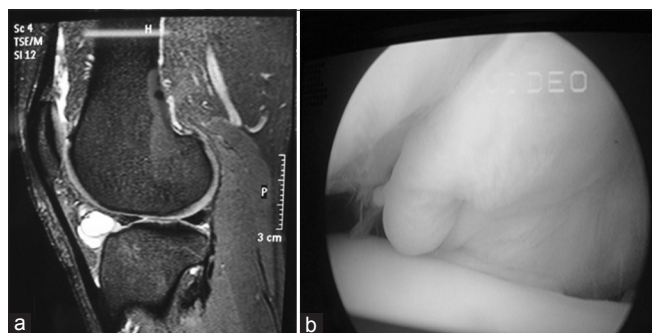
(a) MRI T2WI sagittal images of knee (case 1) showing hyperintense lesion from HFP. (b) Intraoperative arthroscopic picture showing intra-articular extension of cyst
